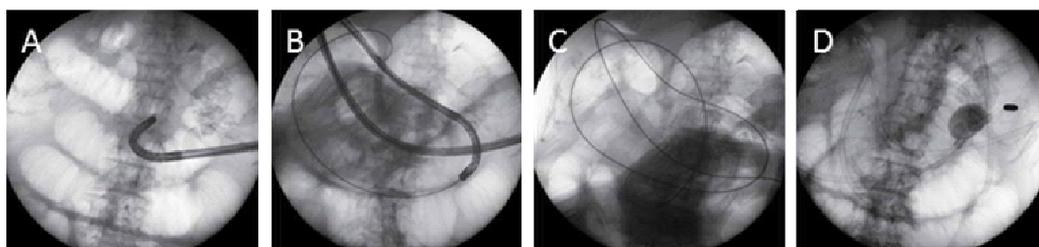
Radiographs of the placement of a long intestinal decompression tube. A. An ultrathin endoscope was inserted into the stomach after removal of the gastrostomy tube. B. The endoscope was advanced to the upper jejunum. C. A guidewire was passed through the endoscope. D. A long intestinal decompression tube (CLINY Ileus Tube, Create Medic Co. Ltd., Yokohama, Japan) was placed over the guidewire.
